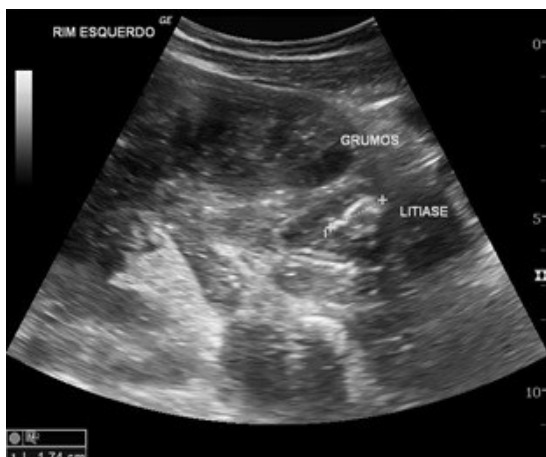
Abdominal ultrasound – debris in collector system and hyperechogenic image with acoustic shadow - staghorn calculus measuring 1,74 cm.
